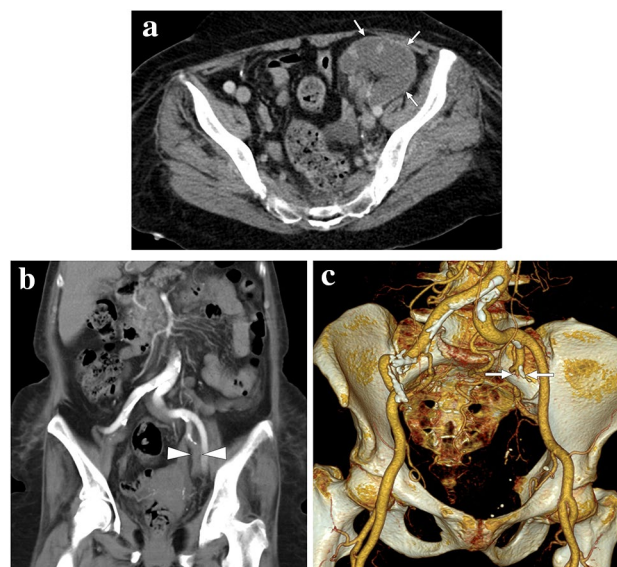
A 65-year-old female with a history of renal transplantation nearly 20 years ago presented with severe, acute left lower quadrant pain. a Axial plane post-contrast CT showed complete devascularization of graft kidney with cortical rim sign (arrows). b and c Coronal plane reformatted CT angiography (b) and 3D-VRT images (c), respectively, demonstrated the acute thrombotic occlusion (arrowheads) and the remaining stump of the renal artery (arrows) anastomosed to the left internal iliac artery
